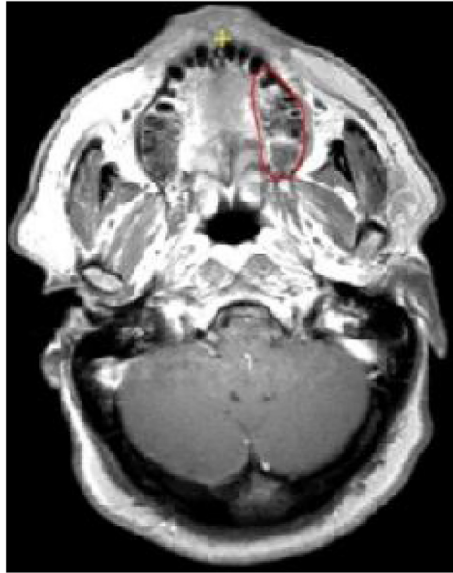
Tumour delineation based on computed tomography and magnetic resonance imaging.
